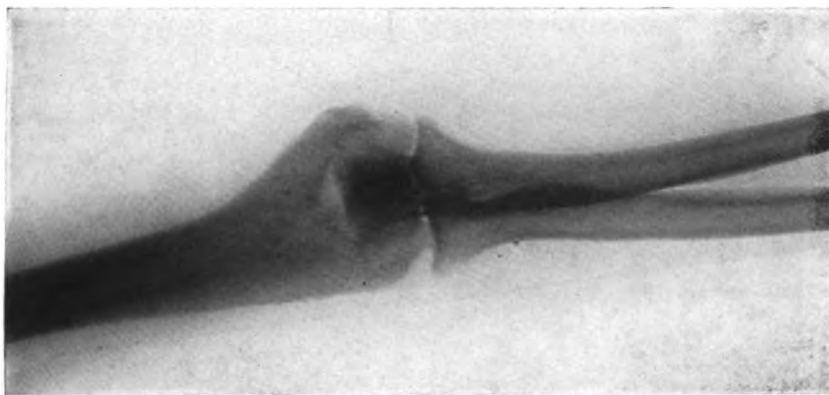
Elbow. X-ray tube in front and plate behind. Case of chronic rheumatism with swelling of the sheath of the ulnar nerve. Elbow appears normal in radiograph.
